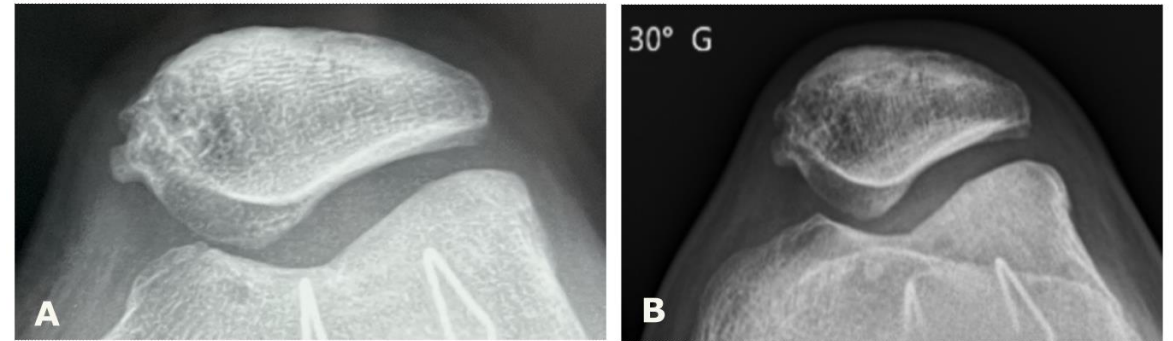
Congruent patellofemoral joint example. (A) Immediate postoperative axial view x-ray of a trochleoplasty patient. (B) 15 years of follow-up axial view x-ray.
